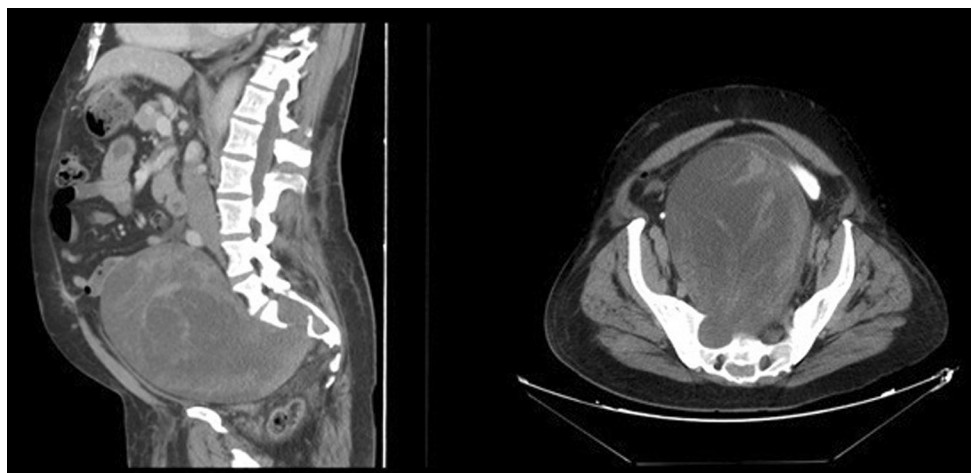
Preoperative lumbar spine CT showing a large retroperitoneal mass. The mass presents hemorrhagic content and it seems to communicate with the spinal canal through an enlarged right S1–S2 foramen with no content inside
